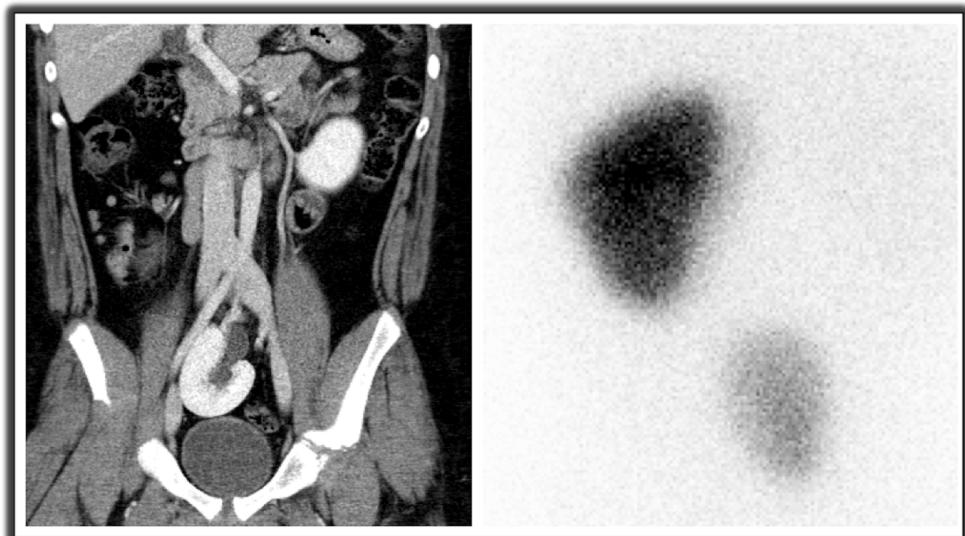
Ectopic pelvic kidney on CT (left) with evidence of decreased differential function on DMSA scan (right).
